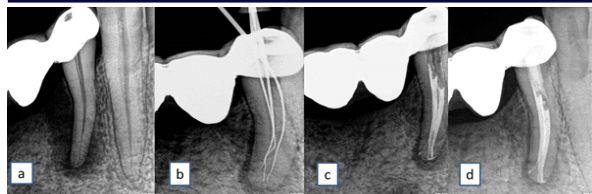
Preoperative view of #34 Fig 1b-Working length determination of #34 Fig 1c- Post obturation radiograph of #34
